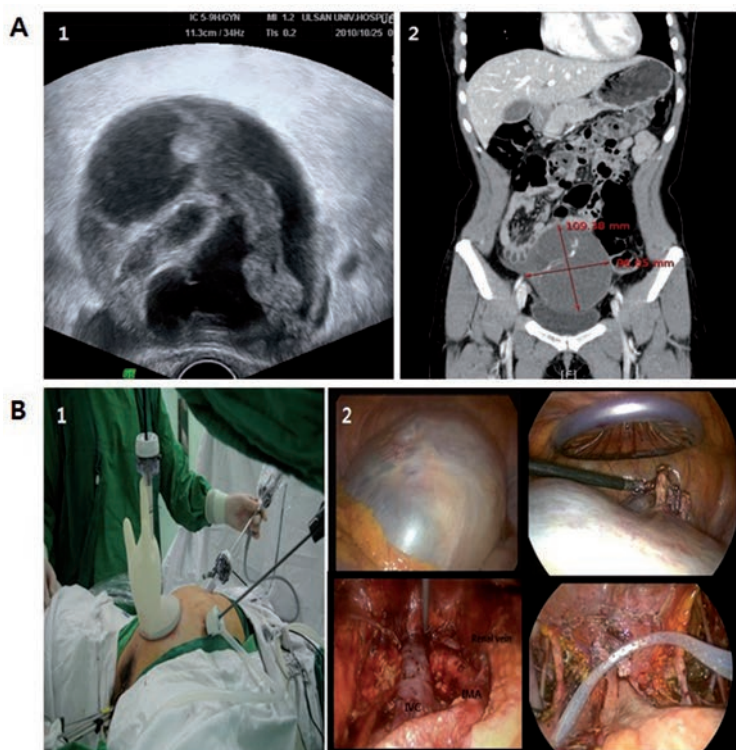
A) Imaging study of non-gestational choriocarcinoma arising in the ovary. Transvaginal sonogram (A-1) and abdomino-pelvic computed tomography (A-2). A 11-cm well-defined complex cystic tumor arising from right adnexa; multiple uneven internal septa with a focus of small solid component B) Surgical view of hand-assisted laparoscopic surgical staging (HALS): preparation view (B-1) and laparoscopic view (B-2).
